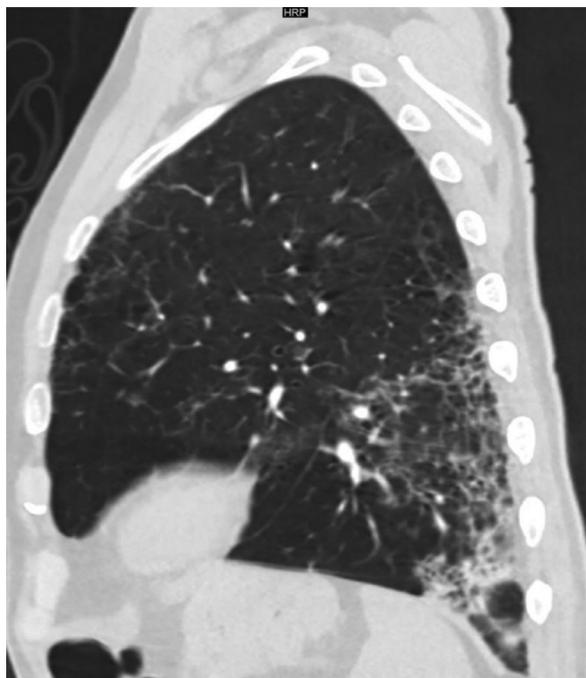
Sagittal reconstruction CT demonstrates mild to moderate lower lobe predominant fibrosis as manifested by pulmonary reticulation, volume loss, architectural distortion, and traction bronchiectasis.
